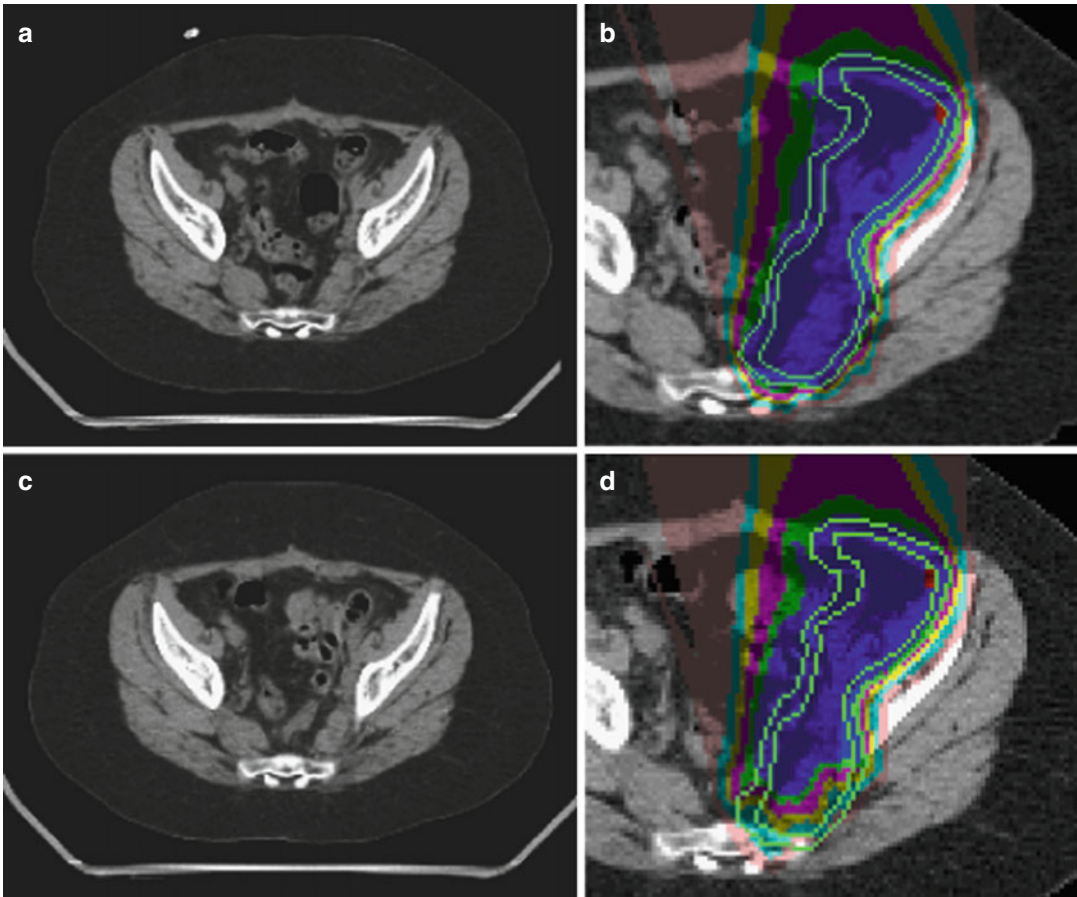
Range and dose perturbations due to changes in intestine filling: (a) Planning CT, (b) Nominal dose distribution calculated on CT in (a), (c) Repeated CT on first fraction, (d) Dose distribution recalculated on repeated CT
